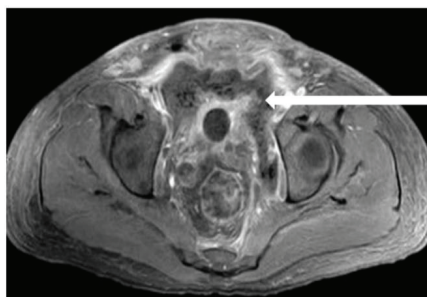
MRI suggested collection in supralelevator space and ischioirectal space extending into left extraperitoneal space.
